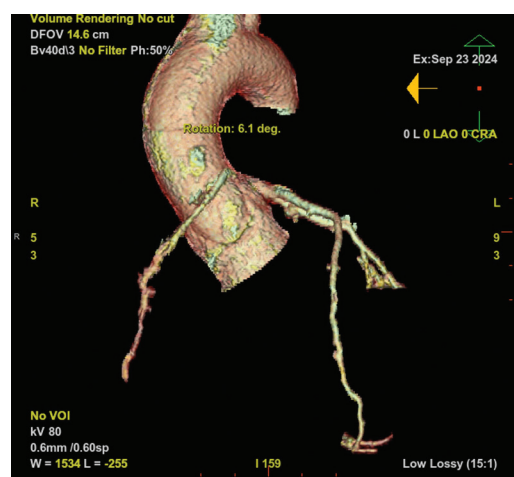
Volume-rendered three-dimensional computed tomography angiography reveals an anomalous aortic origin of the right coronary artery from the left sinus of Valsalva. The right coronary artery follows an interarterial course between the aortic root and pulmonary trunk, a high-risk anatomical variant predisposing to dynamic compression and myocardial ischemia during exertion. The reconstruction further demonstrates a right-dominant coronary circulation, evidenced by the right coronary artery's posterior extension and its contribution to the posterior descending artery and posterolateral ventricular branches.
